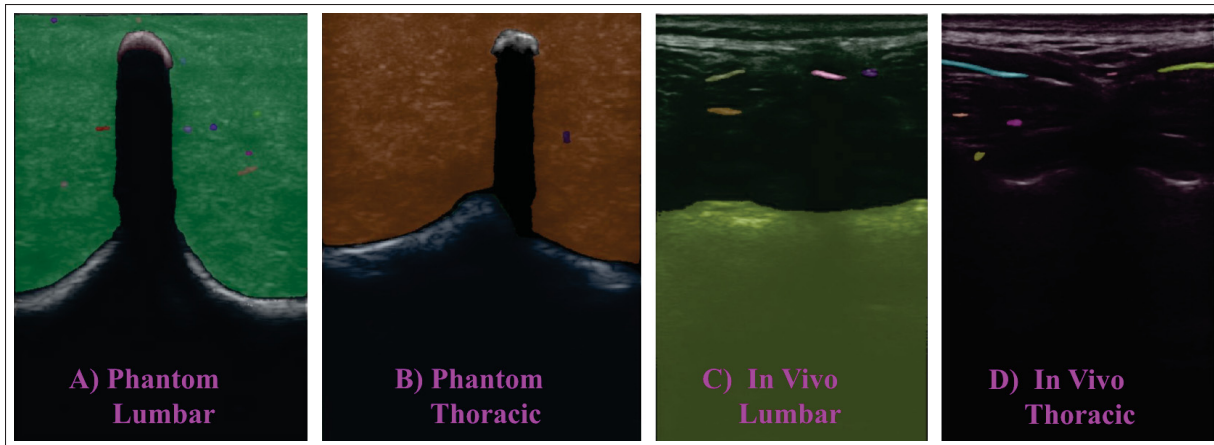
SAM Zero-Shot with no prompts in spinal ultrasound object segmentation
